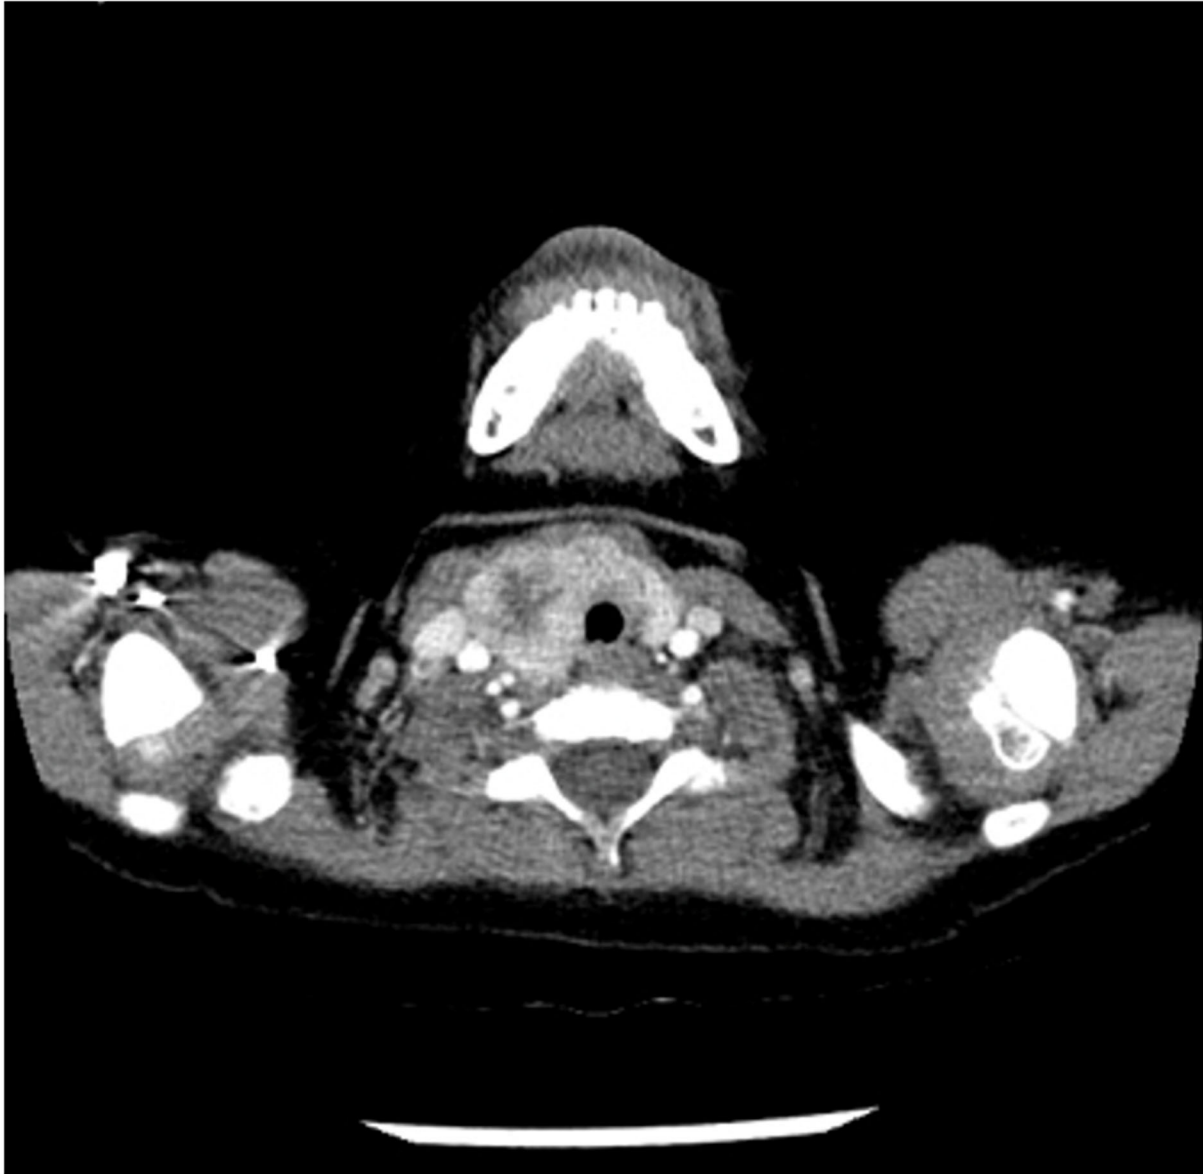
Case 1, CT Scan. Axial CT demonstrates a lobulated and heterogeneous 3.4 x 2.9 x 3.3 cm right thyroid mass extending into the right superior paratracheal space. Abnormal right cervical and bilateral paratracheal lymph nodes and a nonspecific 2 mm left lower lobe pulmonary nodule were also seen. Findings were suggestive of thyroid cancer with cervical nodal metastases.
